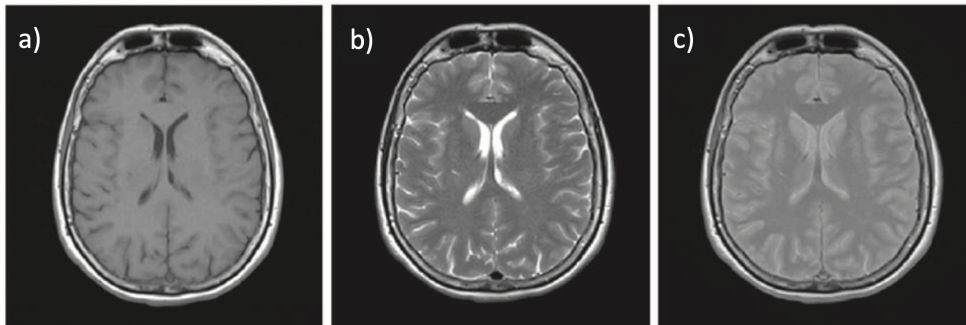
Examples of the different contrasts on a same brain, retrieved from [5](#). The three thirds of the figure represent T1-weighted (a), T2-weighted (b), and proton density-weighted (c) images which result from combinations of varying TR and TE values.*
